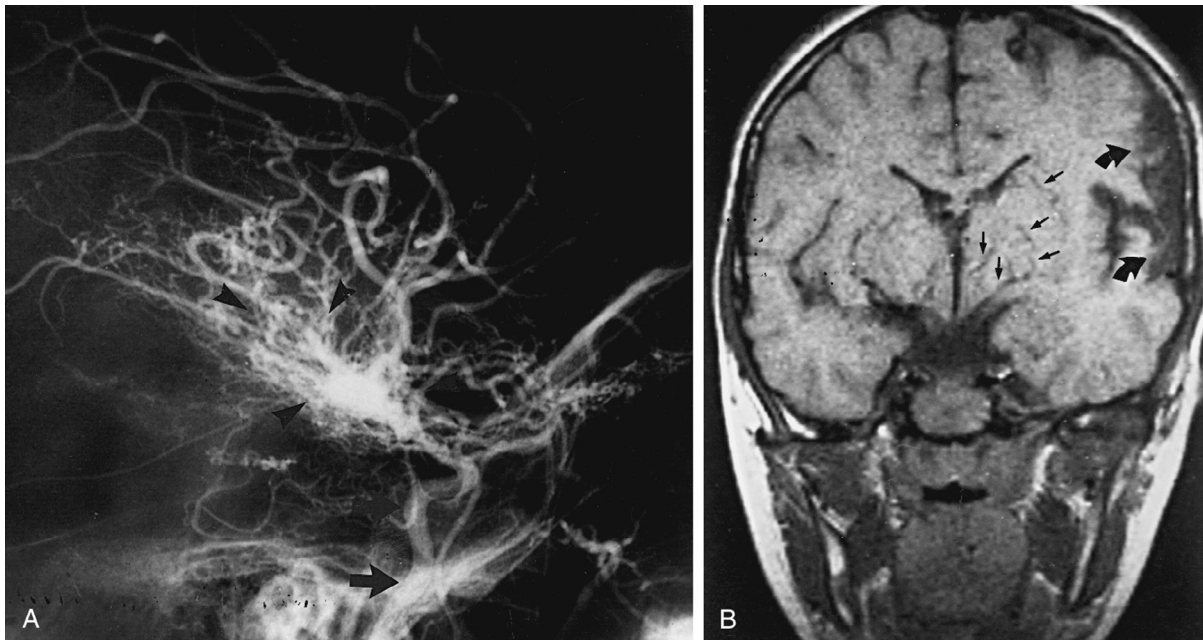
Sudden onset of right hemiparesis in a 6-year-old boy. *A*, Cerebral angiogram shows the left internal carotid artery (*arrow*) leading to a highly arborized, telangiectatic network of vessels (*arrowheads*) typical of moyamoya disease. The typical middle cerebral artery vascular tree is absent. *B*, Cranial coronal magnetic resonance imaging scan shows region of low signal in the middle cerebral artery territory and denotes infarction (*curved arrows*). Flow voids in the basal ganglia (*straight arrows*) are radiographic manifestations of the basilar collateral circulation typical of this vascular anomaly.
